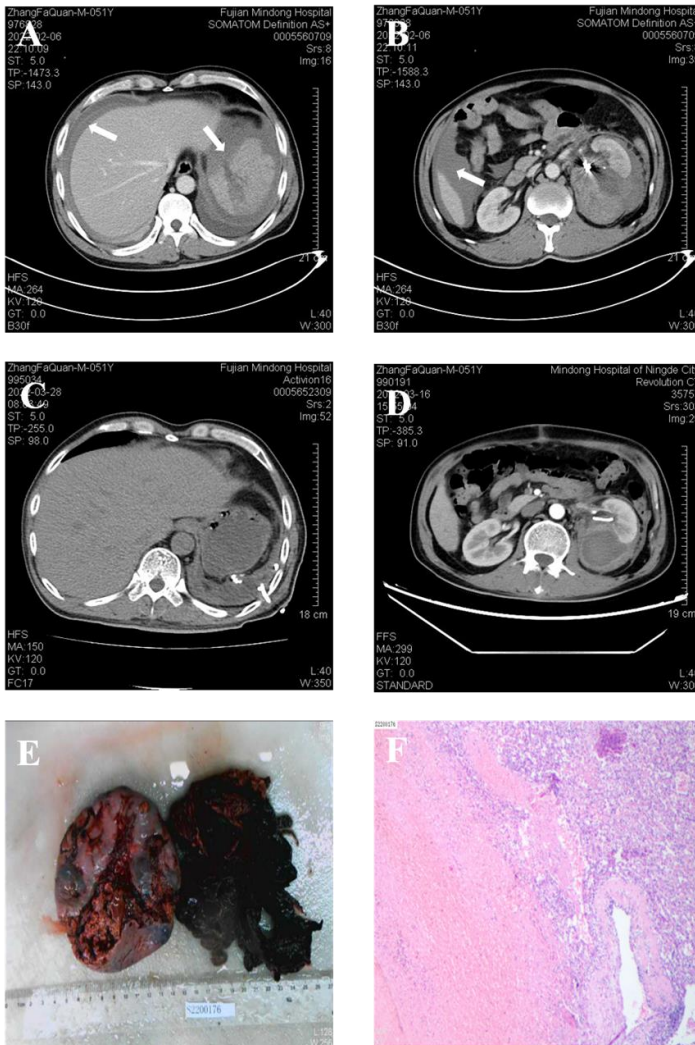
(A, B) Splenorenal artery embolism (of Plain CT scan). White arrow showed the embolized spring coil. (C, D) Coronal CT image of left ureteral D-J tube placement.
